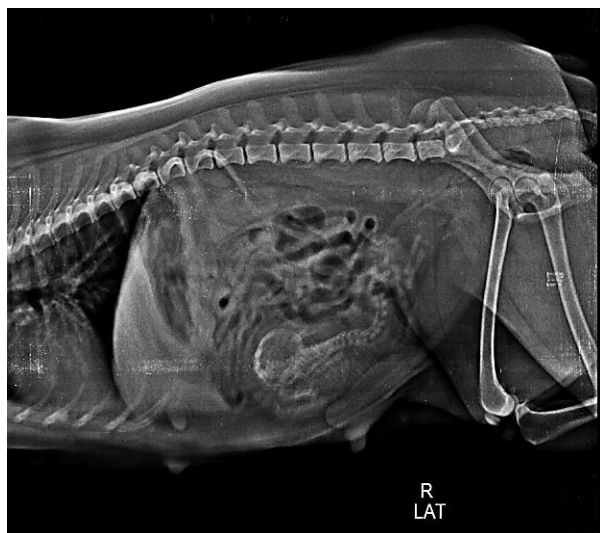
Right lateral radiograph of abdomen showing S-shaped radiopaque mass (foetus).
